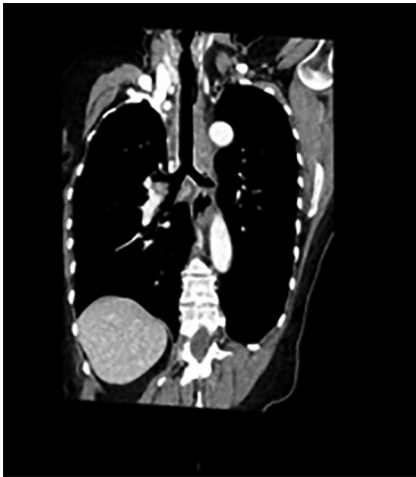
Shown is a case of a stented aortic matrix after airway replacement at CT scan (coronal plane) that benefited from AR2. *CT*, Computed tomography; *AR2*, airway replacement type 2.
